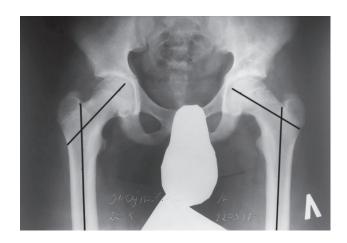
Measurement of neck-to-shaft angle using survey radiograph
